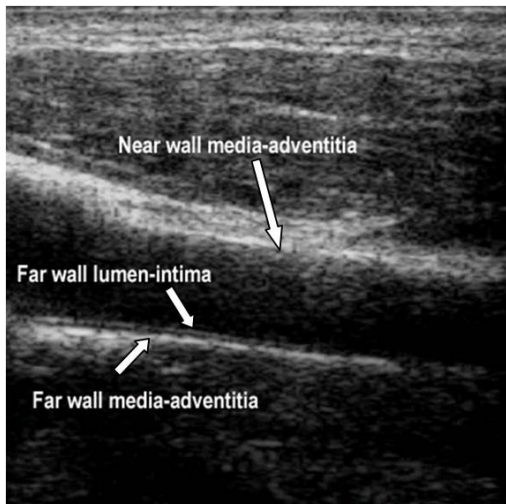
Typical ultrasound B-Mode carotid artery image with the relevant edge/interfaces.
